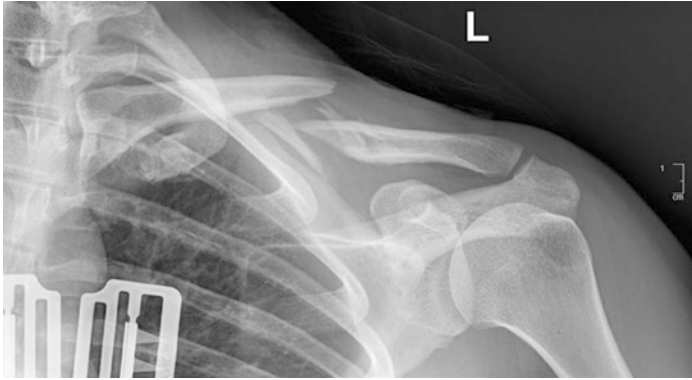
X-ray of the left clavicle
